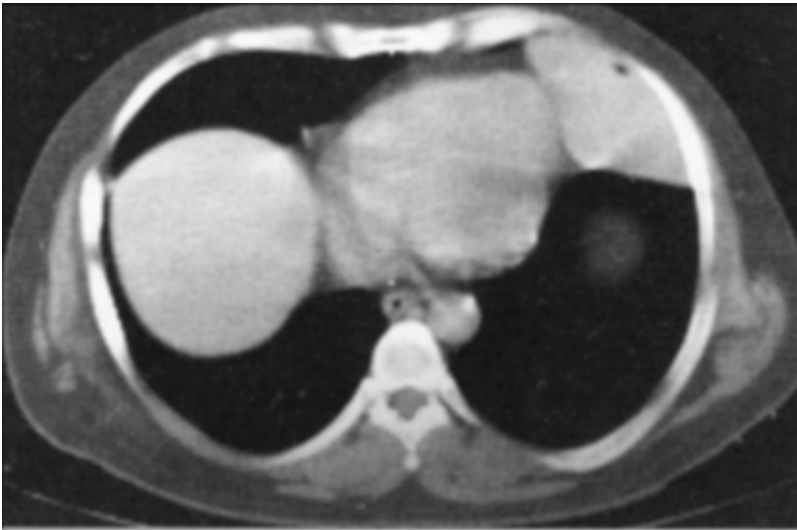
A: Computed tomography (CT) scan of large solitary fibrous tumor of the pleura. B: Thoracotomy view of solitary fibrous tumor.
